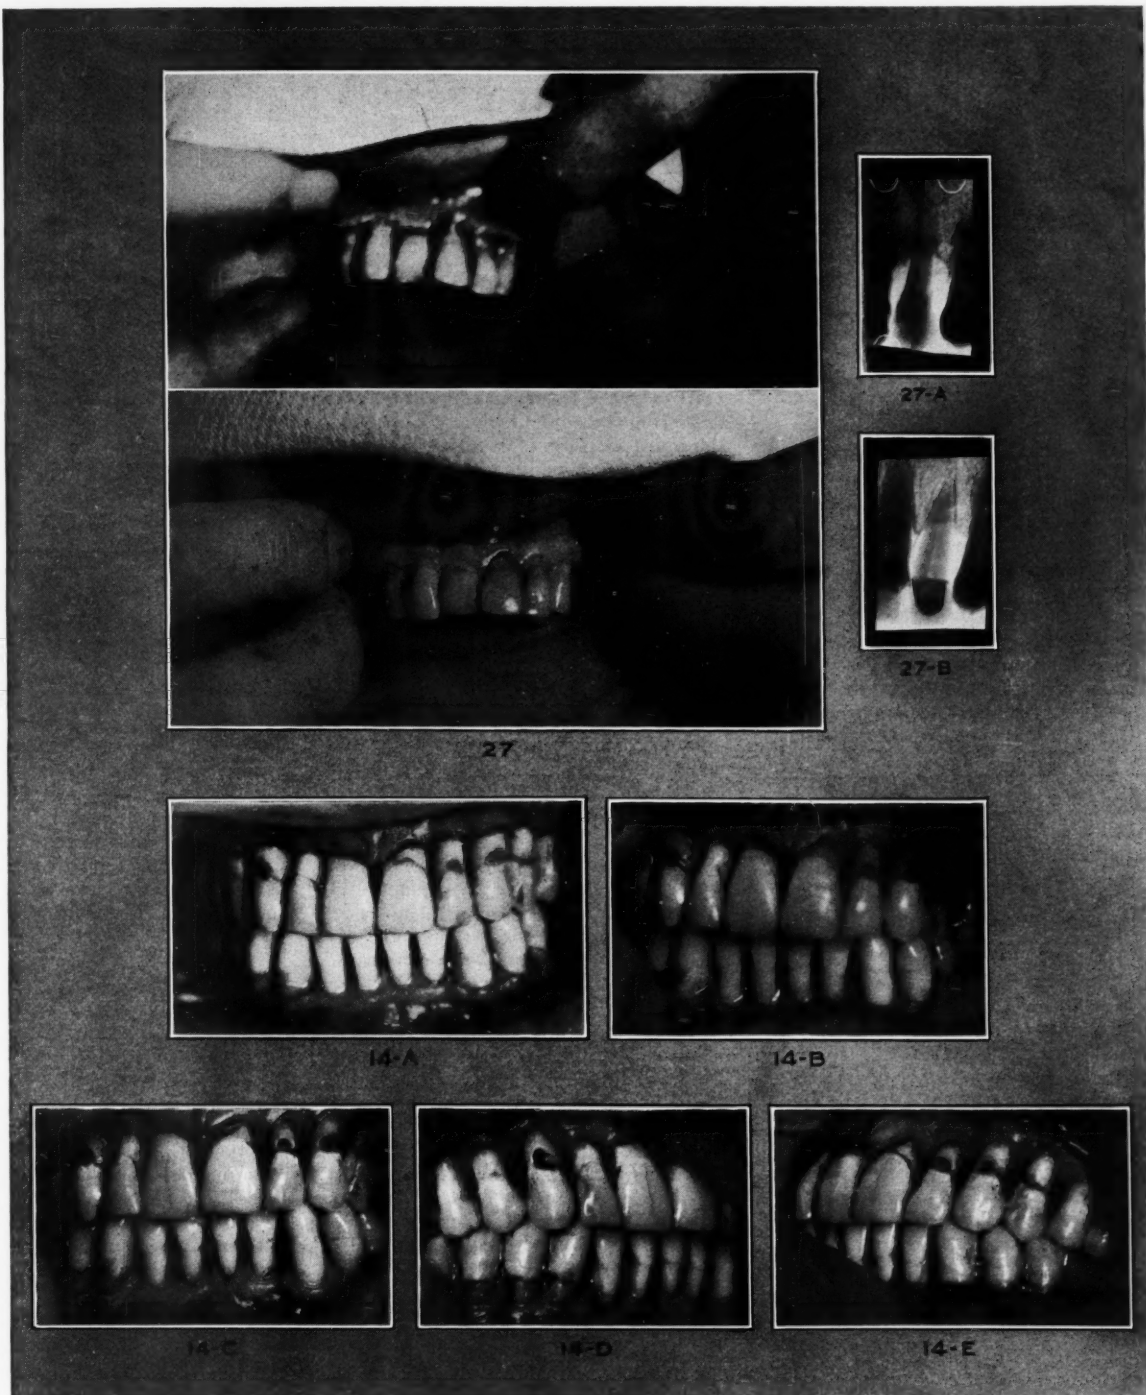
Upper, immediately after removal of pack. Note thick irregular gum margin. Lower, same case, thirteen months later. Roentgenograms show the bone repair in the worst pocket. (A), before operation; (B), thirteen months after operation.
